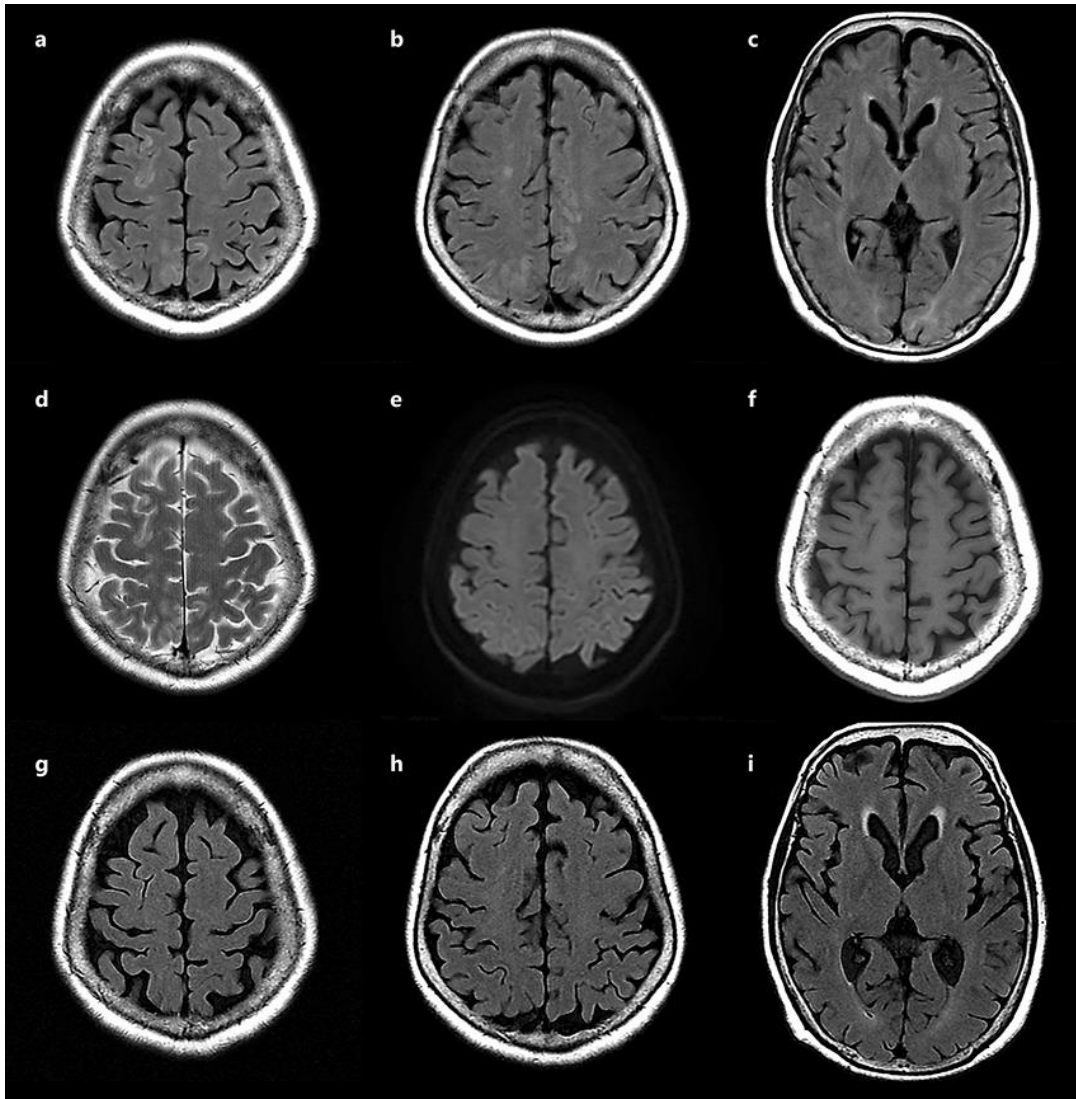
Brain MRI of the patient. a–c, g–i FLAIR. d T2WI. e DWI. f T1WI. a–f At the onset. Bilateral subcortical altered signal intensities involving U-fibers of the frontal-parieto-occipital lobes are shown. g–i Follow-up MRI performed before steroid administration. All lesions had disappeared.
